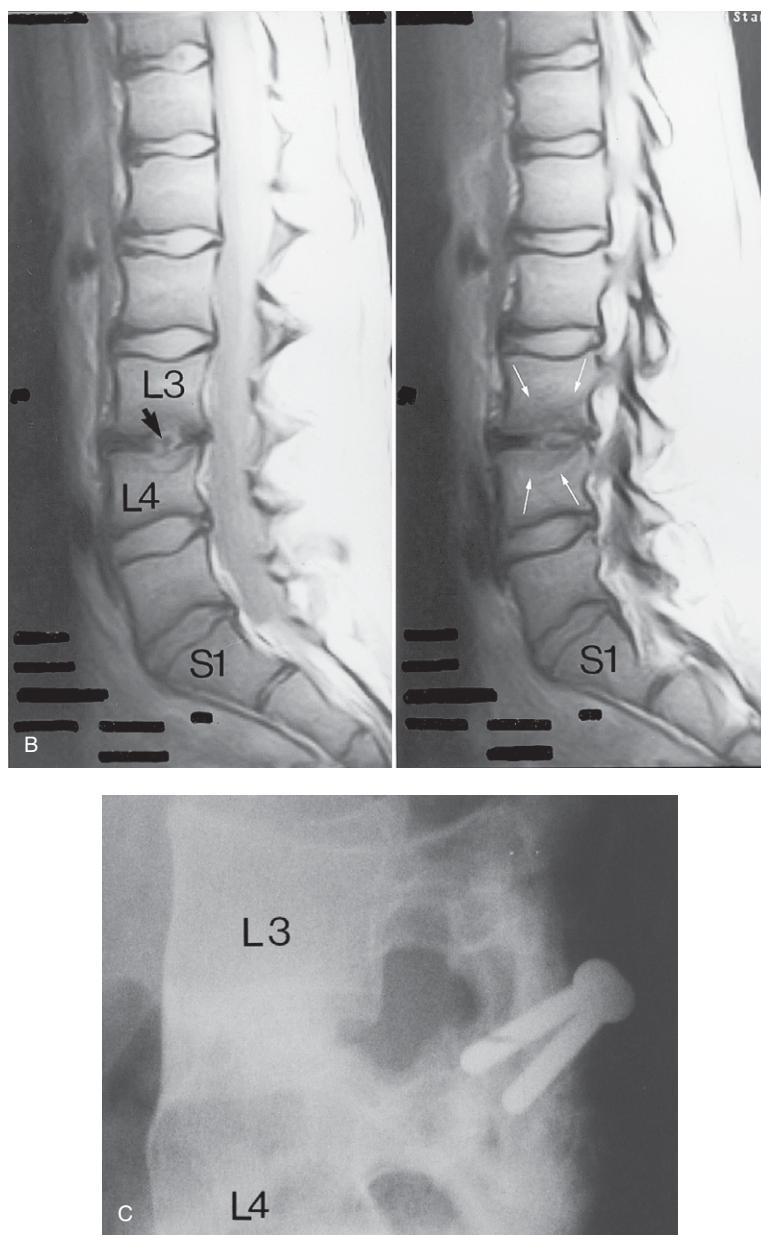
Cont'd (B) Lumbar spine MRI parasagittal STIR image showing discitis of the L3–4 disc with destruction of the adjacent vertebral body endplates and associated marrow oedema (arrows). There is a small degree of enhancement of this disc posteriorly (black arrow). The remaining discs appear normal. L3 = third lumbar vertebral body; L4 = fourth lumbar vertebral body; S1 = first sacral segment. (C) A lateral plain X-ray image of the L3 and L4 bodies showing an anterior interbody fusion with posterior fixation (using two screws).
